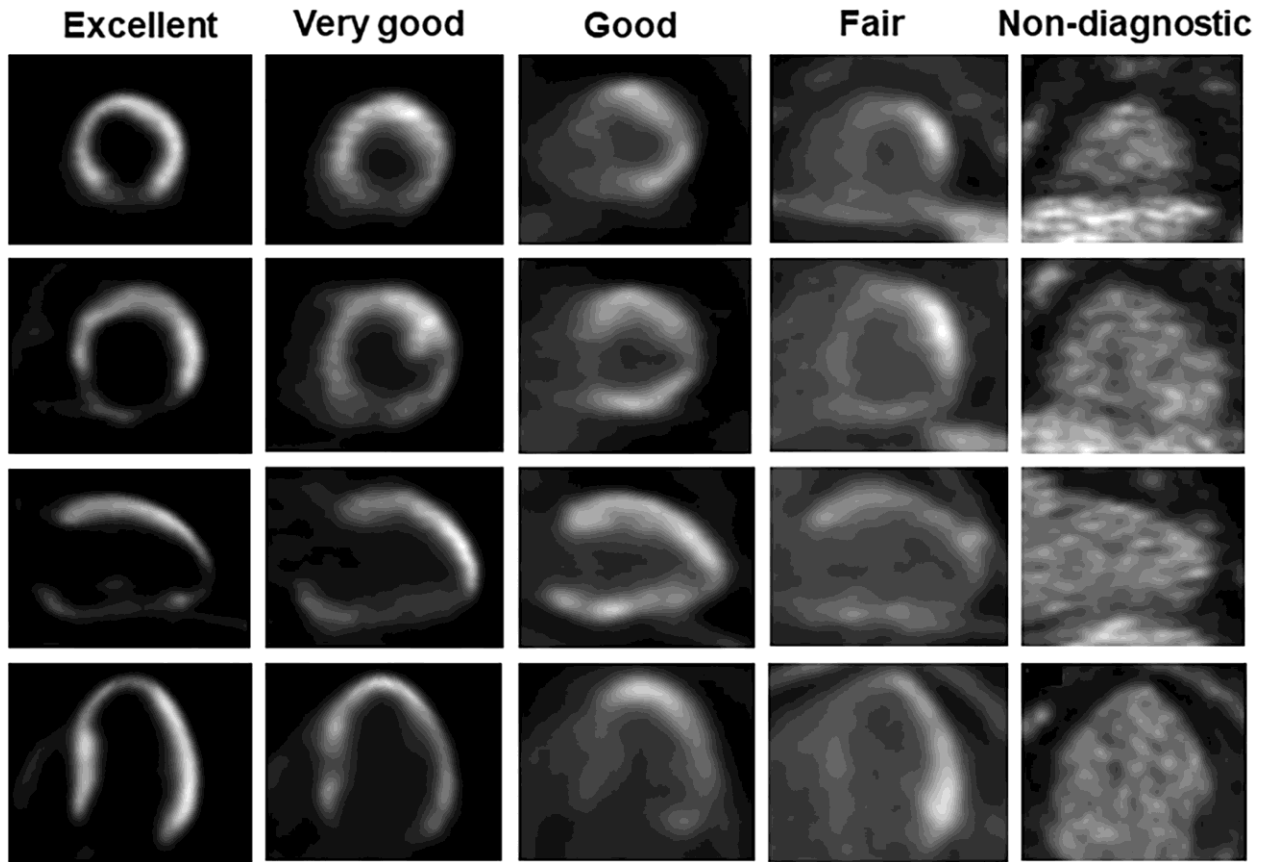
Myocardial ^{18}F -FDG image quality was evaluated according to a 5 point score system.
